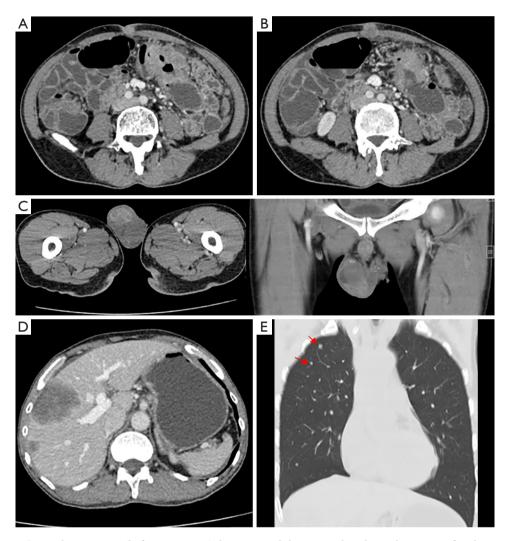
CT scan on September 10, 2019 (before treatment) demonstrated that unevenly enhanced segment of mid transverse colon can be seen, thickest wall with locally constricted lumen and blurry surrounding lipoid space, periumbilical abdominal wall nodule can be seen, an irregular nodule can be seen below the right testicle with bilateral hydrocele, metastatic nodes can be seen in liver segments S4-8, Multiple metastatic nodules can be seen in the lung (red arrows).
